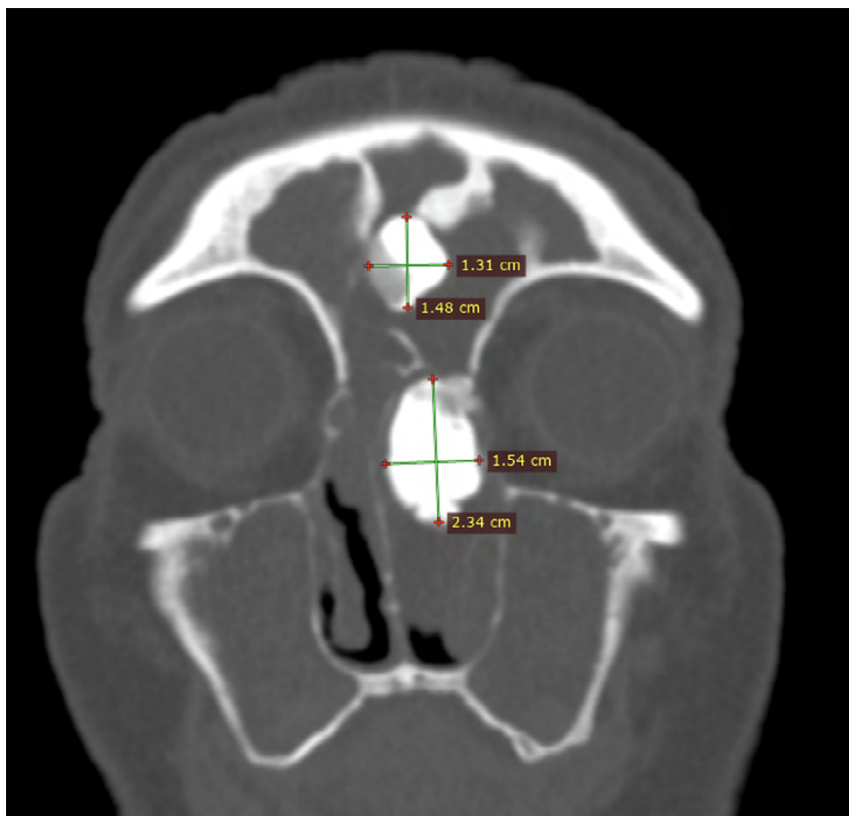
Computed tomography image of osteomas in ethmoid and frontal sinus with diameter of the osteomas measured in coronal projection.
